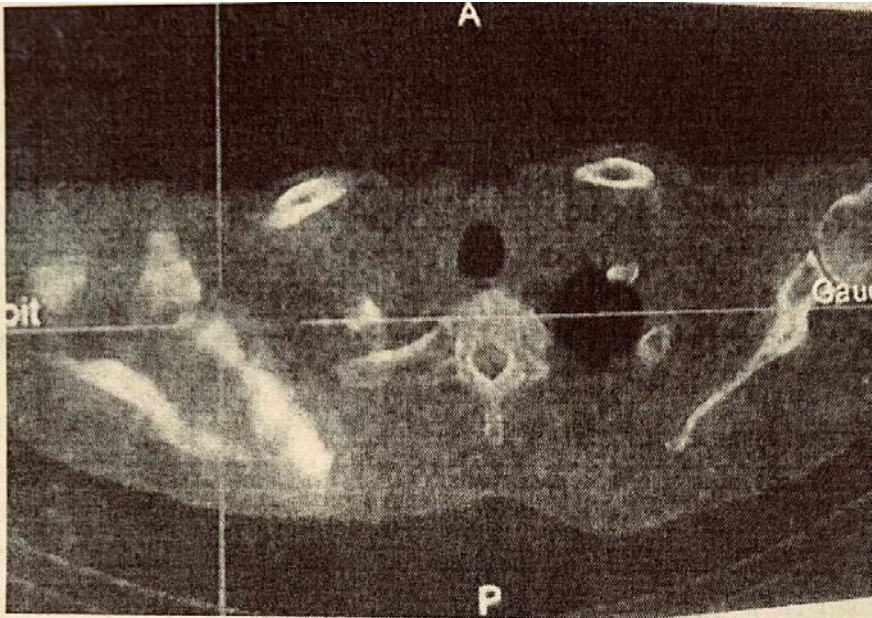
Chest computed tomography axial cut scan showing a tumor process on the right scapula
